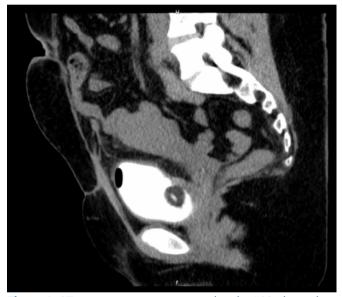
CT-cytogram on post-operative day#21 showed no contrast extravasation. Foley catheter was removed.
